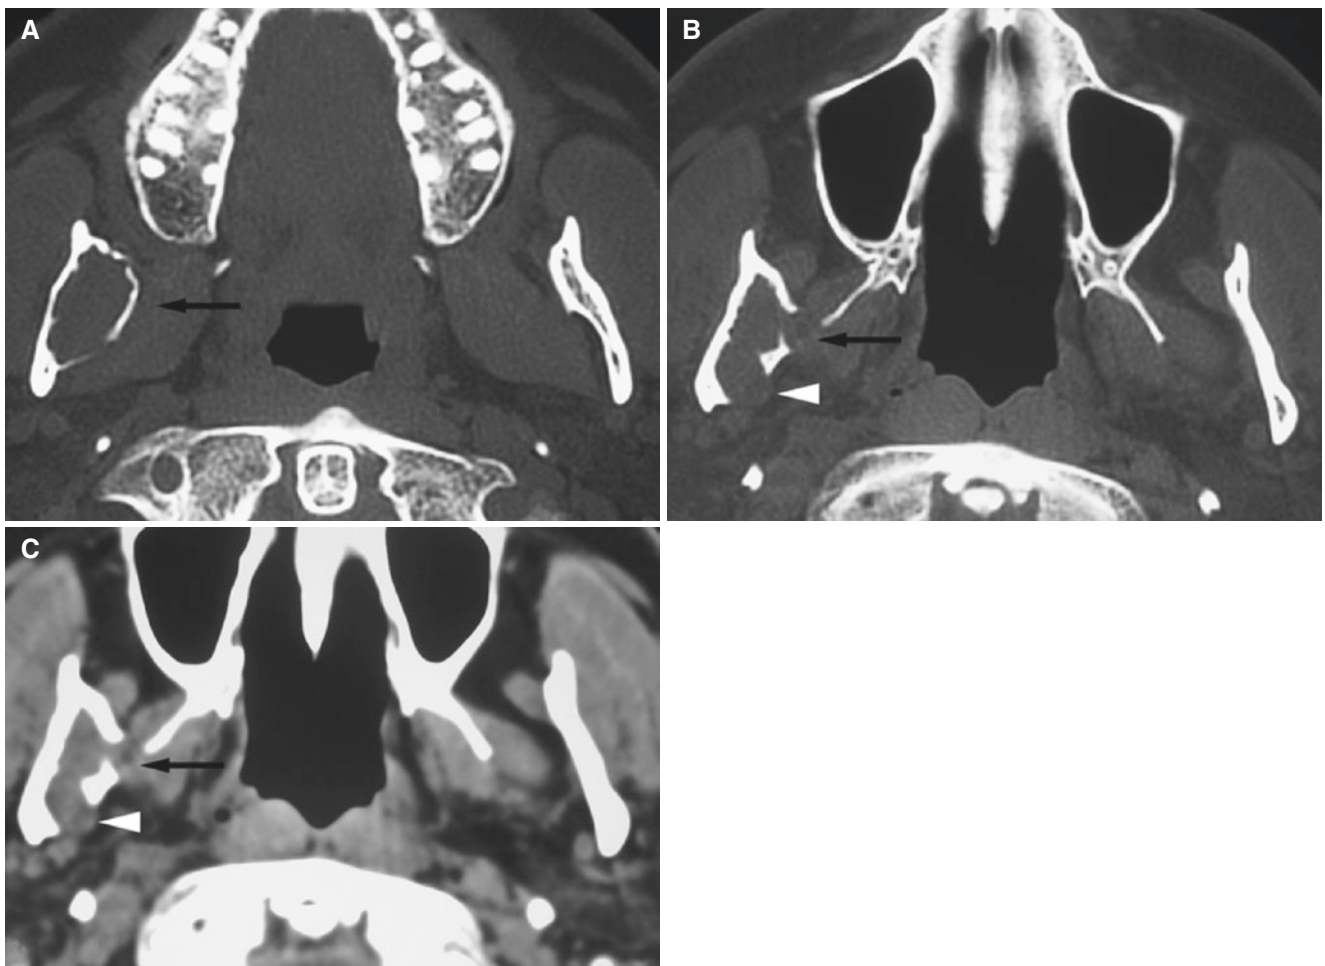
Ameloblastoma, solid/multicystic, mandible; 45-year-old male with incidental finding at routine dental radiography. (A) Axial CT image shows unilocular expansive process with nearly intact cortical bone (*arrow*). (B) Axial CT image, another section, shows cortical
